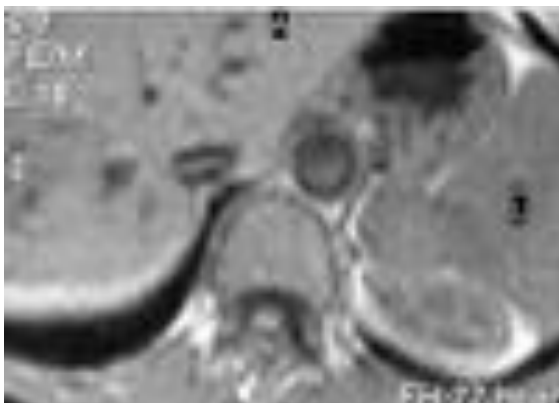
MR images show accessory spleen (arrow) isointense with main spleen as an adrenal mass.
